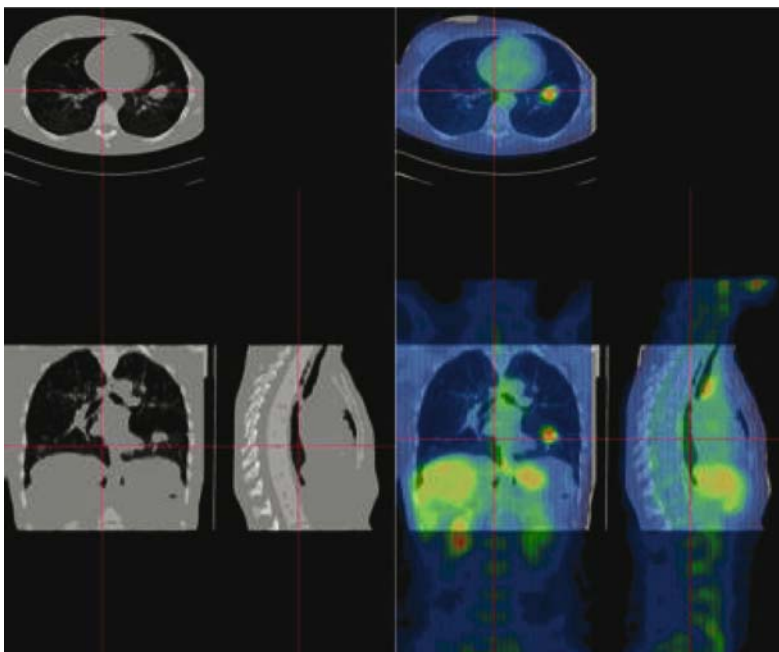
An example of linear image registration applied to the fusion of thoracic CT with whole-body  $^{18}\text{F}$ -FDG PET. Both scans were acquired with similar breathing patterns.
